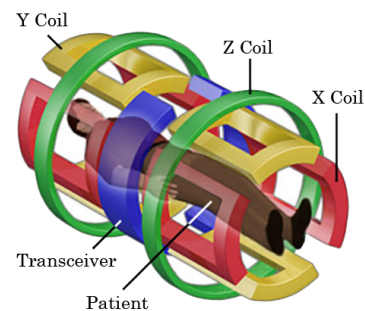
MRI Scanner Gradient Coils. ²⁾
